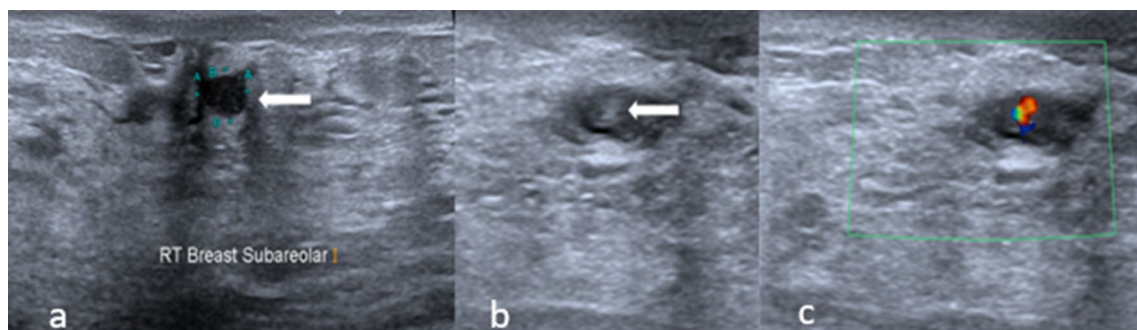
a A tubular hypoechoic lesion in the subareolar region of the right breast around 11 o'clock position suggestive of dilated duct. b A linear hyperechoic focus within the dilated duct. c Color Doppler showing mixed red-blue signals within
